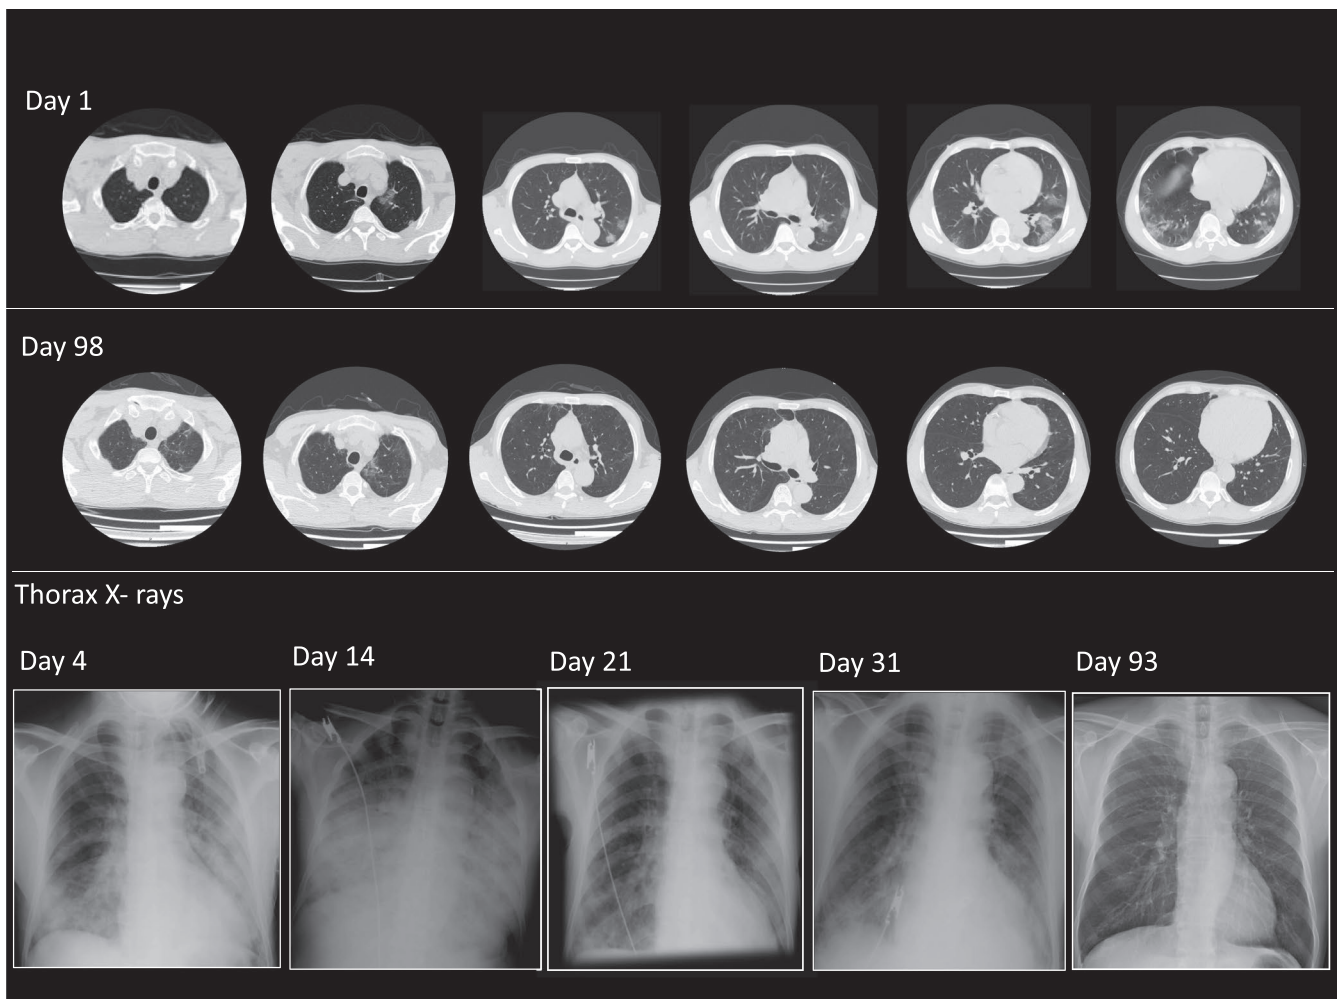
Imaging follow-up by CT scan and thorax X-rays. Bilateral ground-glass areas were present on CT scans at day 1, followed by rapid worsening of multifocal pneumonia and vascular congestion from day 4 to day 14. Partial improvement of both inflammatory infiltrates and fluid congestion was observed on days 21 and 31. Extended follow-up to days 93 and 98 revealed almost complete resolution, excepting apical fibrotic lesions on left lung
